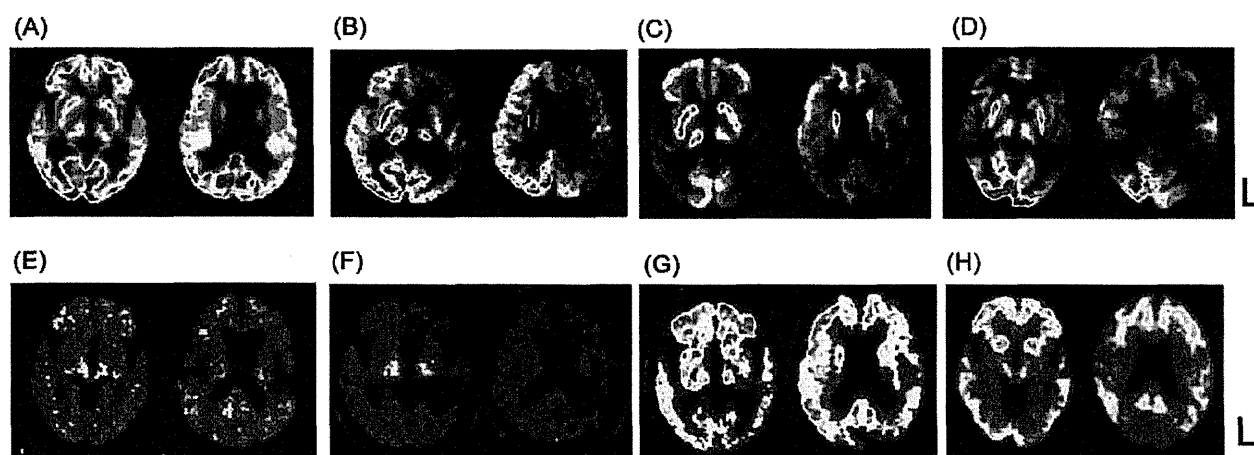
FDG-PET and ^{11}C PiB-PET. (A) In naPPA patients, FDG-PET analysis showed glucose hypometabolism in the left posterior fronto-insular region. (B) ^{11}C PiB-PET showed no abnormal signal lesion in the brain of naPPA patients. (C) In svPPA patients, FDG-PET showed glucose hypometabolism in the left anterior temporal lobe, while no PiB positive signal finding in cerebral cortices (D). (E) While lvPPA patients showed glucose hypometabolism in the left anterior temporal lobe by FDG-PET, ^{11}C PiB-PET showed abnormal high PiB signal findings in cerebral cortices of frontal lobes and temporal lobes and the posterior cingulate (F). (G) An early-onset AD patient showed glucose hypometabolism in bilateral frontal and temporal lobes, presenting abnormal PiB positive signal findings in cerebral cortices and the posterior cingulate in ^{11}C PiB-PET (H).
